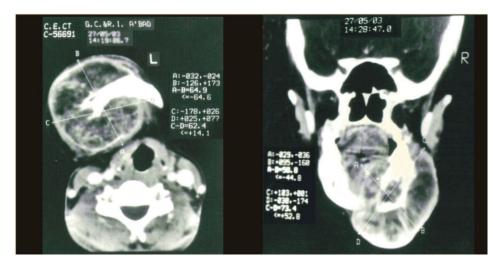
CT scan axial and coronal view of mandible showing erosion, destruction and periosteal new bone formation with extraosseous mass at right side
